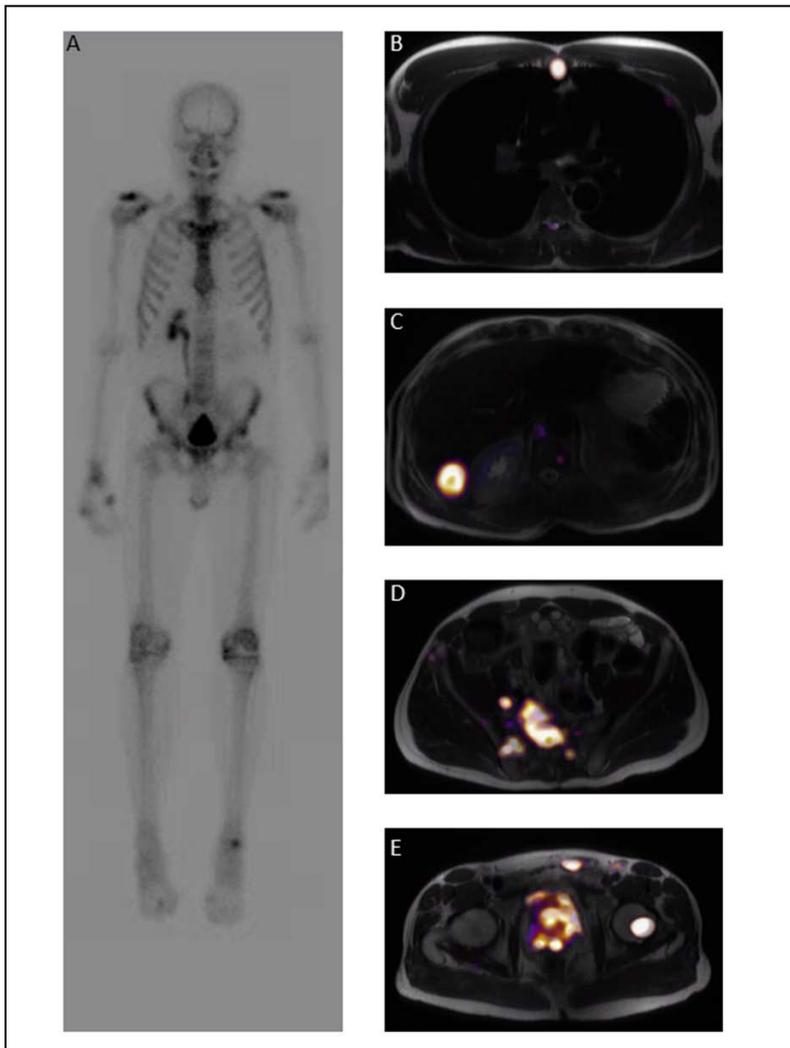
Patient with new diagnosis of high risk prostate cancer. Pre-therapy scans shown. A) Nuclear medicine Tc99m-MDP bone scan shows no evidence of osseous metastatic disease. A CT exam at that time demonstrated one suspicious lymph node abutting the right ureter causing hydronephrosis. B-E) RSI-MRI at selected axial slices shows sternal metastasis (B), hepatic metastasis (C), multiple lymph nodal and osseous pelvis metastases (D,E). NOT FOR DISTRIBUTION.
